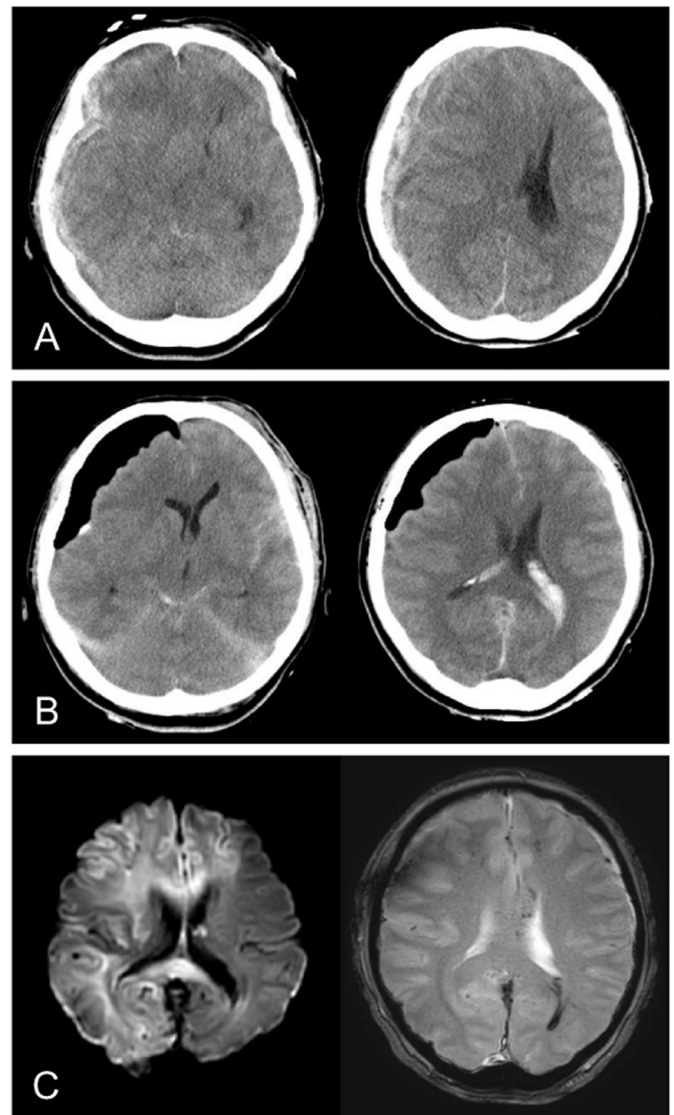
A: CT scans obtained on admission revealing right frontotemporal acute subdural hematoma with midline shift, diffuse traumatic subarachnoid hemorrhage, intraventricular hemorrhage, and marked brain swelling. B: Postoperative CT scans demonstrating almost complete evacuation of the hematoma and improvement in the extent of midline shift. C: Diffusion-weighted magnetic resonance imaging performed on postoperative day 9 (left) showing large ischemic damage. T2*-weighted gradient echo imaging (right) demonstrates microbleeds in the bilateral frontal lobe and corpus callosum, indicating diffuse axonal injury.
